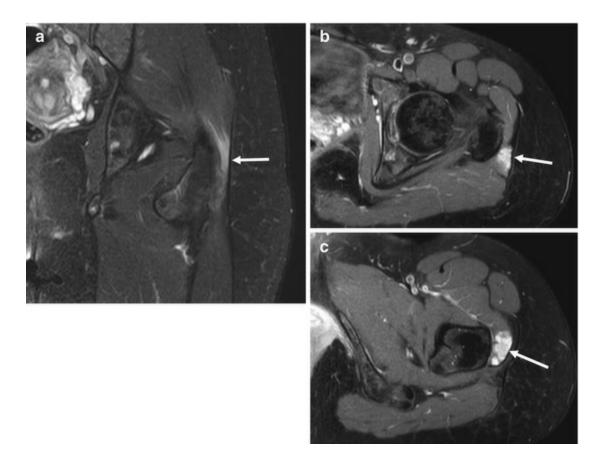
A 30-year-old woman presenting with peri-trochanteric pain after a long time in a hammock. Coronal (a) and axial (b) fat-suppressed T2-weighted MRI show intra muscular focal areas of T2-hyperintensity at the gluteus maximus around the greater trochanter. Similar findings are present at the proximal portion of the vastus lateralis muscle (*arrow*, c). These findings are compatible with compressive myopathy of the gluteus maximus and vastus lateralis
